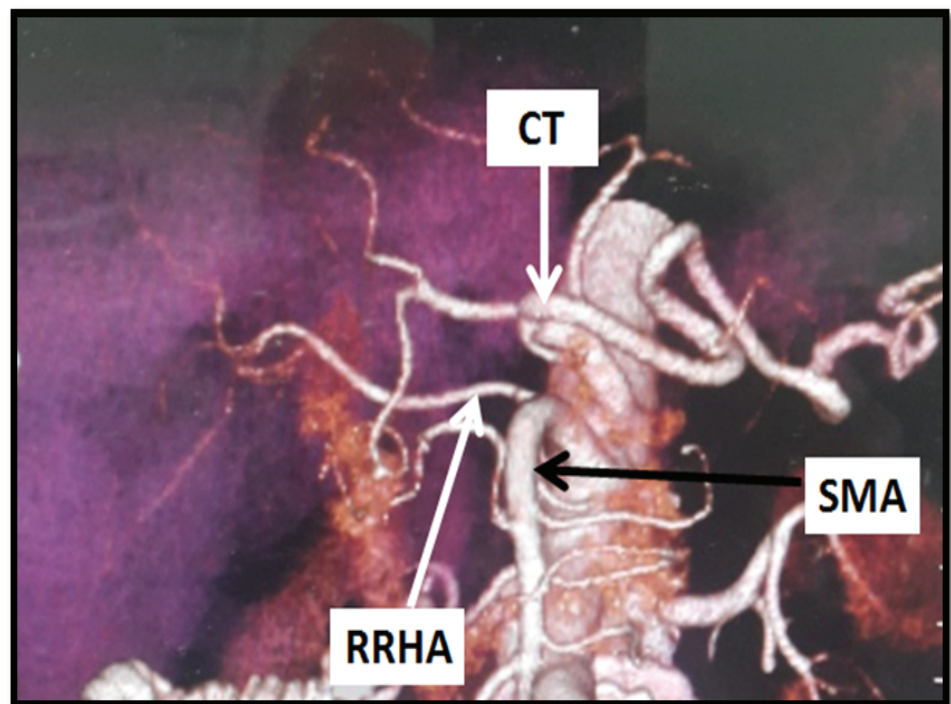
CT angiography of Toshiba AquilionTM 64 slice (Toshiba Medical Systems, Nasu, Japan) showing Michel type III replaced right hepatic artery from superior mesenteric artery + quadrification of the celiac trunk.
